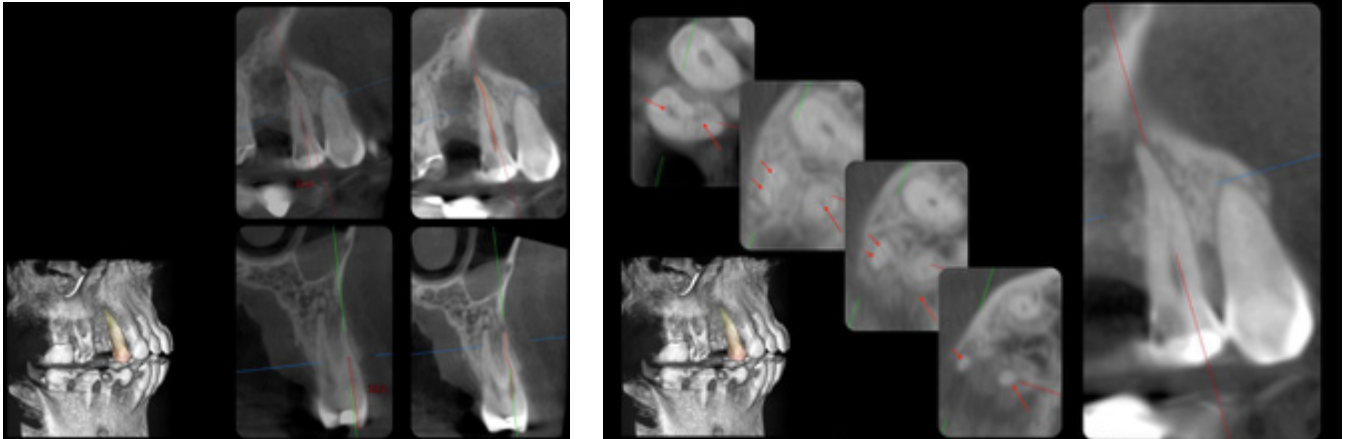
& 3 The CBCT images reveal two canals merging in the apical region, while the palatal canal posed no challenges.
